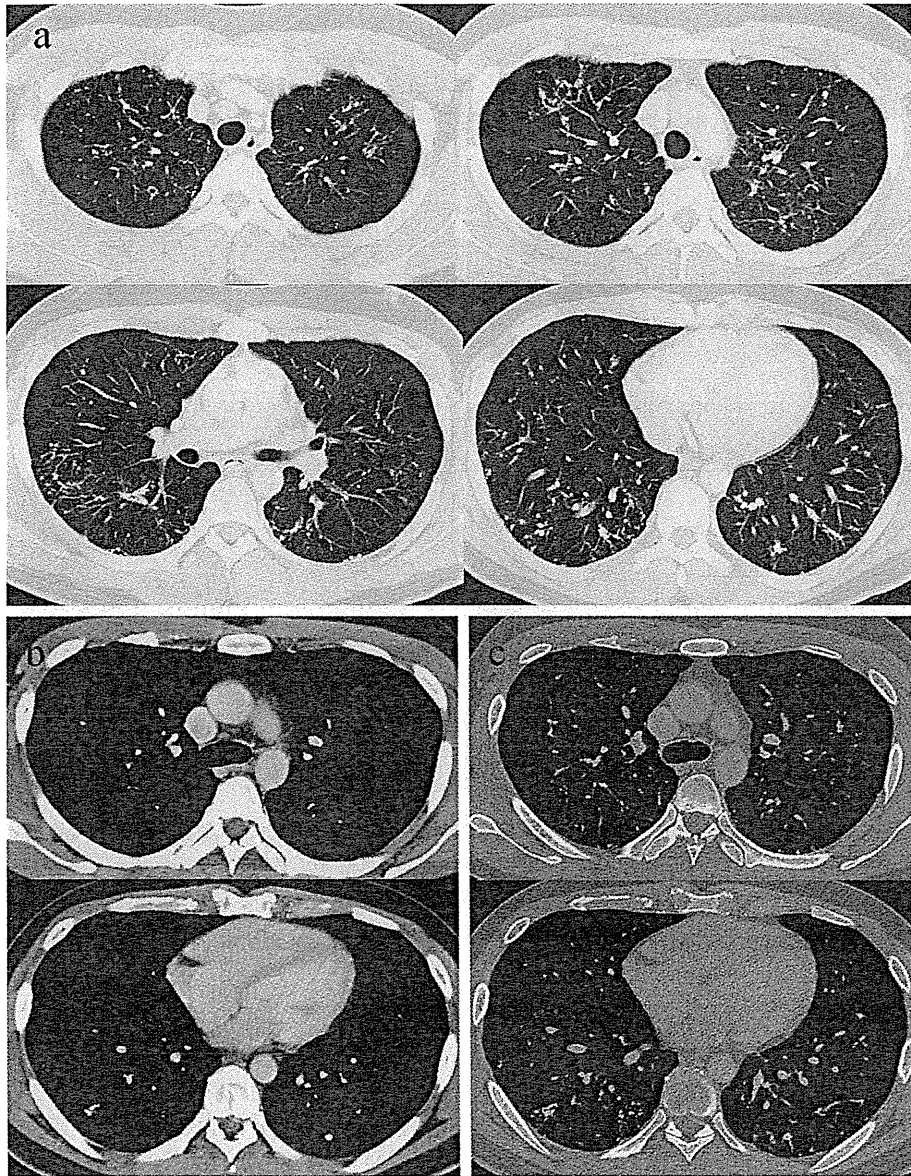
Computed tomography (CT) performed on admission. CT images demonstrated linear and reticular opacities with, in part, diffuse calcification in all the lung fields bilaterally (a, b). The CT opacities were similar to bone (c).
